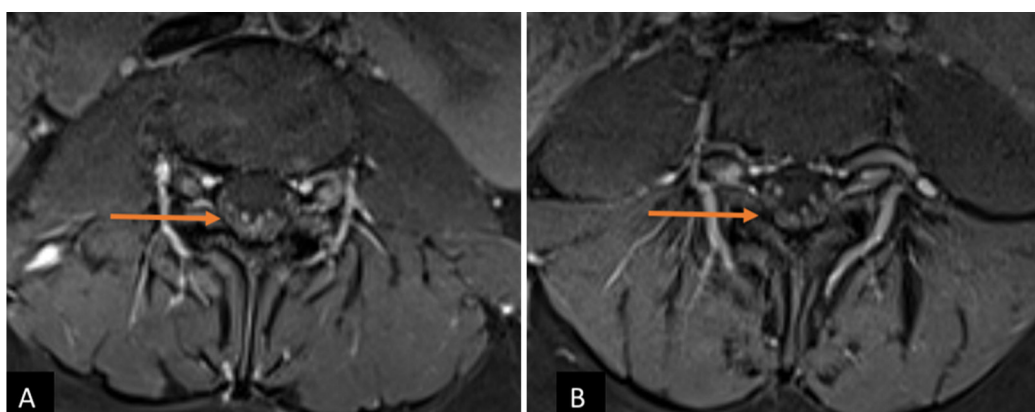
Arachnoiditis. Axial post contrast MRI images (A, B) of the lumbar spine, show posterior layering with thickening and enhancement of the lumbar nerve roots (arrow).
